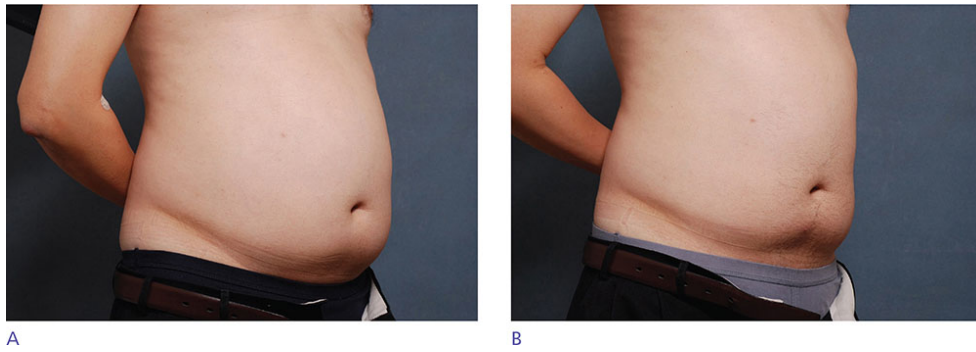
(A) Baseline abdomen. (B) Two months after single treatment of high-intensity focused ultrasound.
